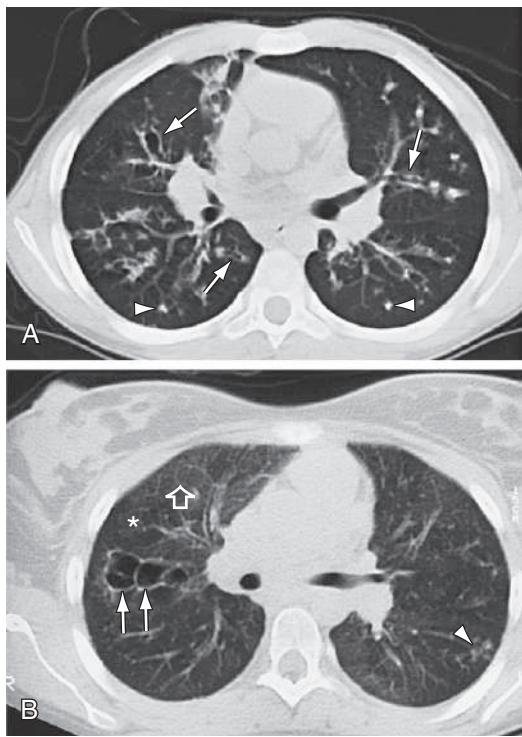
CT scans of the chest in cystic fibrosis. A, A 12-yr-old male with moderate lung disease. Airway and parenchymal changes are present throughout both lungs. Multiple areas of bronchiectasis (arrows) and mucous plugging (arrowheads) can be seen. B, A 19-yr-old female has mostly normal lung with one area of saccular bronchiectasis in the right upper lobe (arrows) and a focal area of peripheral mucous plugging in the left lower lobe (arrowhead). Lung density is heterogeneous with areas of normal lung (open arrow) and areas of low attenuation reflecting segmental and subsegmental air trapping (asterisk).
